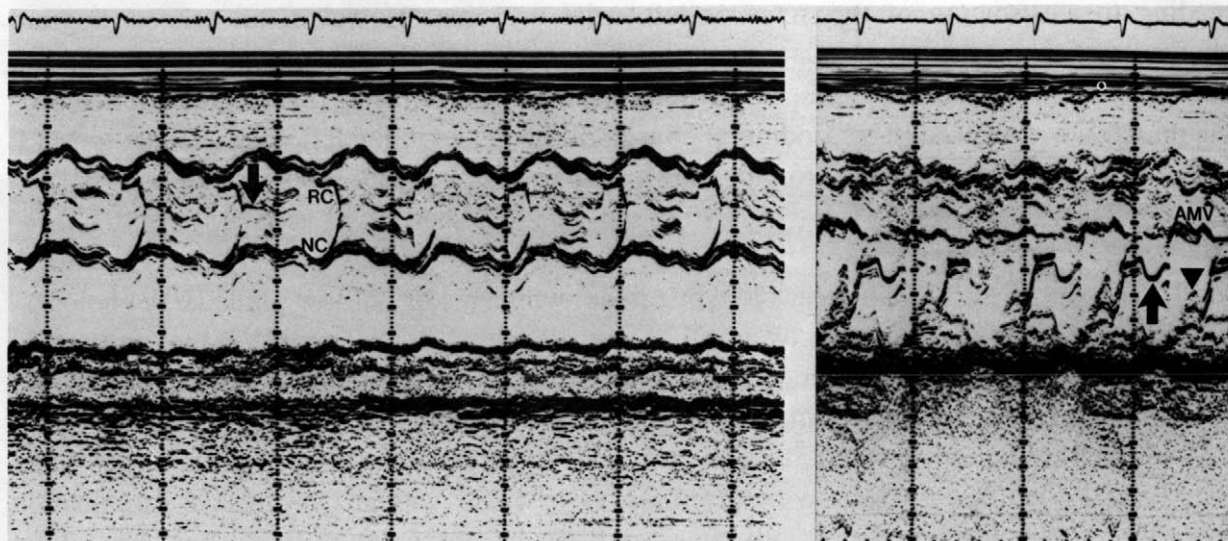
(Left) Normal aortic valve M-mode echocardiogram trace. Closure of leaflets during diastole (arrow) and normal opening of right coronary leaflet (RC) and noncoronary leaflet (NC) during systole. (Right) Abnormal mitral valve M-mode echocardiogram trace. Billowing of the posterior mitral leaflet during end systole (arrow), anterior mitral leaflet during diastole (AMV), and multiple echoes of the posterior mitral valve and chordae tendinae (arrowhead) representing chaotic motion and excursion of the valve into the left ventricle, resulting in the filling defect seen on the RNV.
